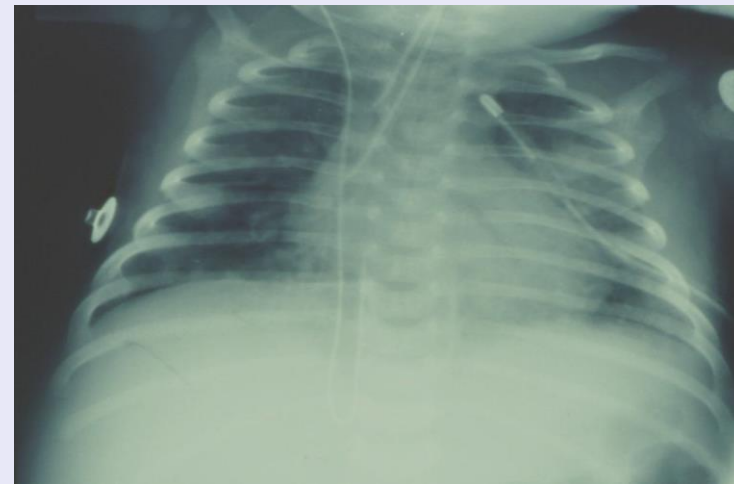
Chest x-ray of neonate intubated selectively using two single lumen tubes. One tube is in trachea and the other selectively intubates the right bronchus.
